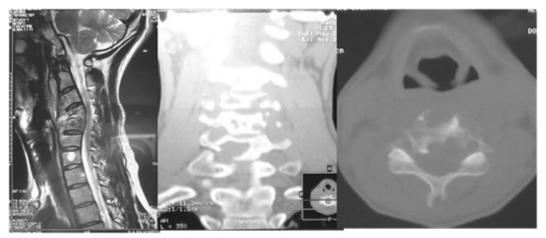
MRI and CT show abnormal signals of C3-6 vertebral body and paravertebral body, and some bone destruction.
